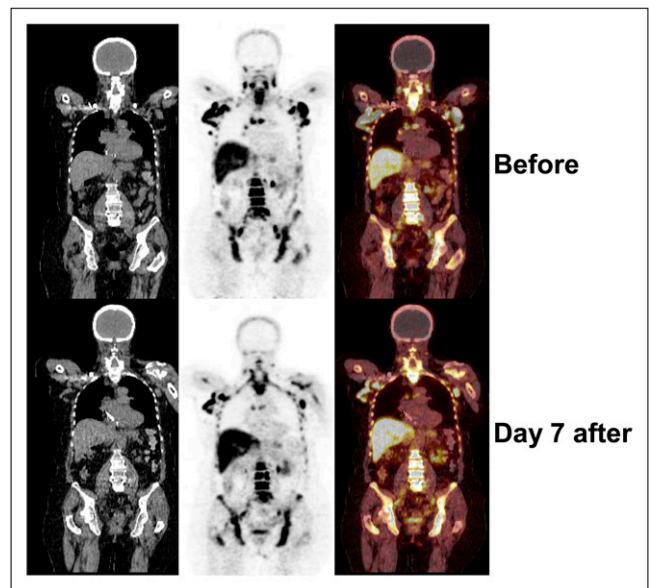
Early response assessment by ^{18}F -FLT PET. Shown are images of patient 5 before initiation of immunochemotherapy and at day 7 after initiation of chemotherapy. SUV_{mean} and SUV_{max} decreased by 38% and 35%, respectively.
